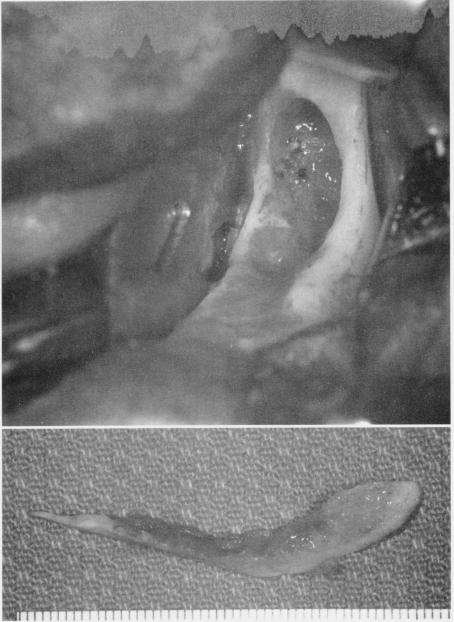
Osteoradionecrosis of the left mandible. This patient had a full course of tumoricidal radiotherapy for squamous cell carcinoma. The dentition was removed at the time of the cancer resection. This patient was prepared for treatment of the osteoradionecrosis with pre- and postoperative hyperbaric oxygen treatments. A, Exposed devital bone along alveolar ridge of left mandible. B, Panoramic radiograph showing diffuse irregularity without good cortication of alveolar crest. C, Surgical exposure of the area shows devital bone margins and a central crater devoid of bone.
